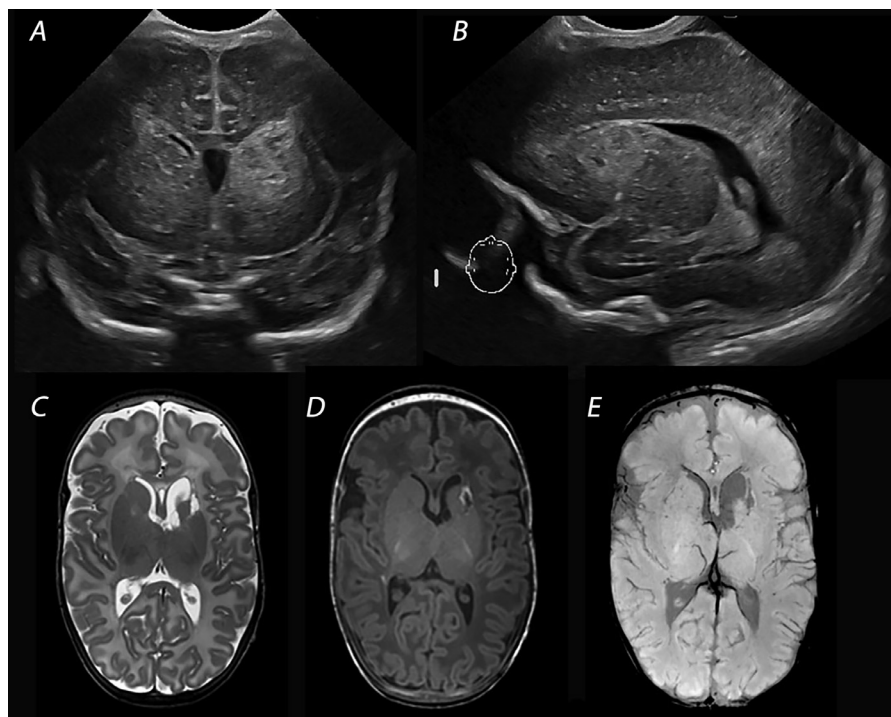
Part of monozygous diamniotic twins with TAPS, born at 29 weeks/ birthweight 1250 g. cUS on day 2 shows a wedge shaped echogenic lesion on the left caudate nucleus region, A) coronal and B) sagittal view. The MRI at TEA shows cystic evolution with some ex-vacuo dilatation of the left ventricle (C) as well as a germinolytic cyst. On the T1 (D) the cyst has a high signal intensity rim. The SWI (E) does not show low signal intensity suggestive of a hemorrhage. Anterior cerebral artery perforator stroke.
